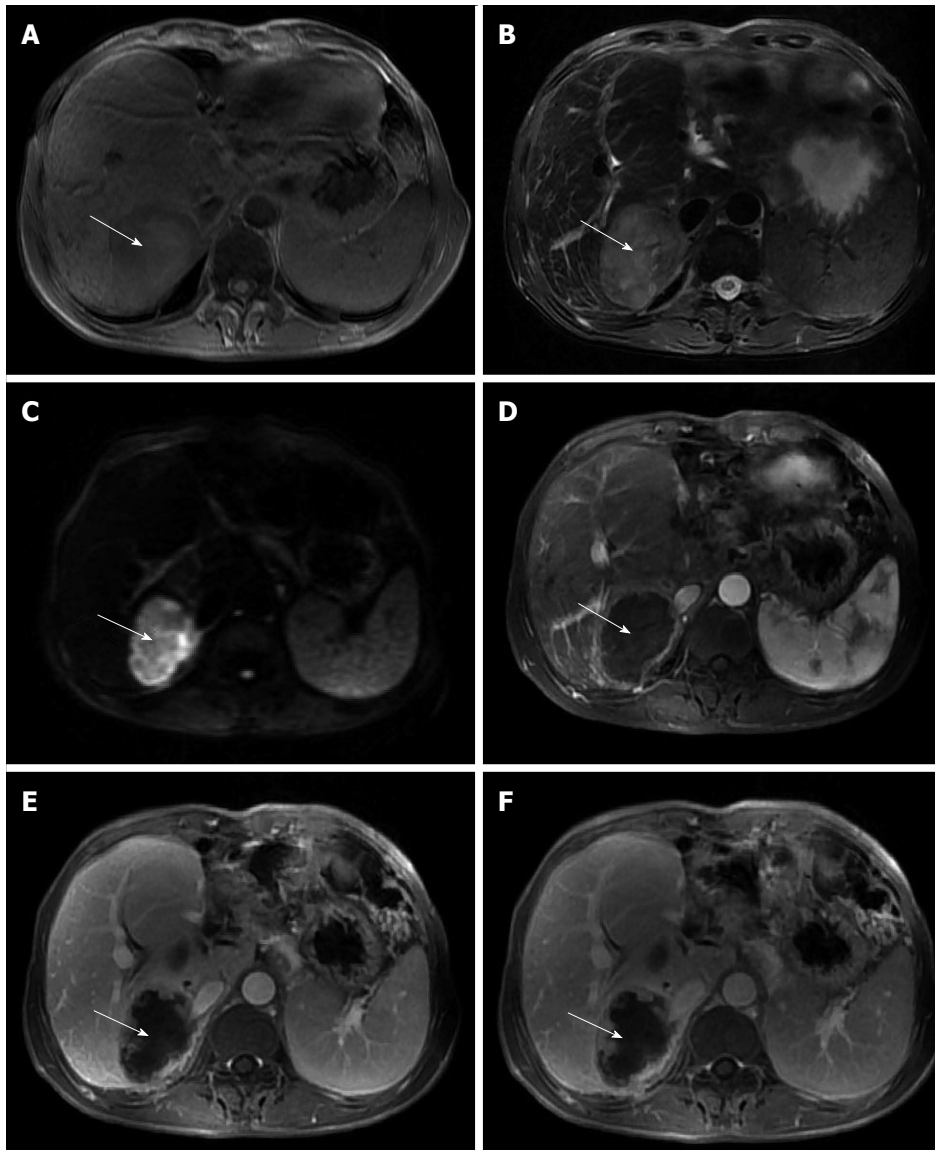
Magnetic resonance imaging. A: Markedly heterogeneous low signal intensity mass (white arrow) in the right lobe of the liver on T1-weighted imaging, with focal areas of high signal intensity that indicate fresh hemorrhage; B: Heterogeneous high signal intensity mass (white arrow) in the right lobe of the liver on T2-weighted imaging, with focal areas of higher signal intensity that indicate necrosis or hemorrhage; C: Mass (white arrow) shows high signal intensity on diffusion-weighted imaging that reveals restricted diffusion; D: Mass (white arrow) has a ring-like enhancement in the arterial phase; E: Progressive enhancement of the ring (white arrow) in the portal phase, revealing nodular enhanced foci within the ring; F: Progressive enhancement of the ring (white arrow) and nodular enhanced foci within the ring in the delayed phase.
